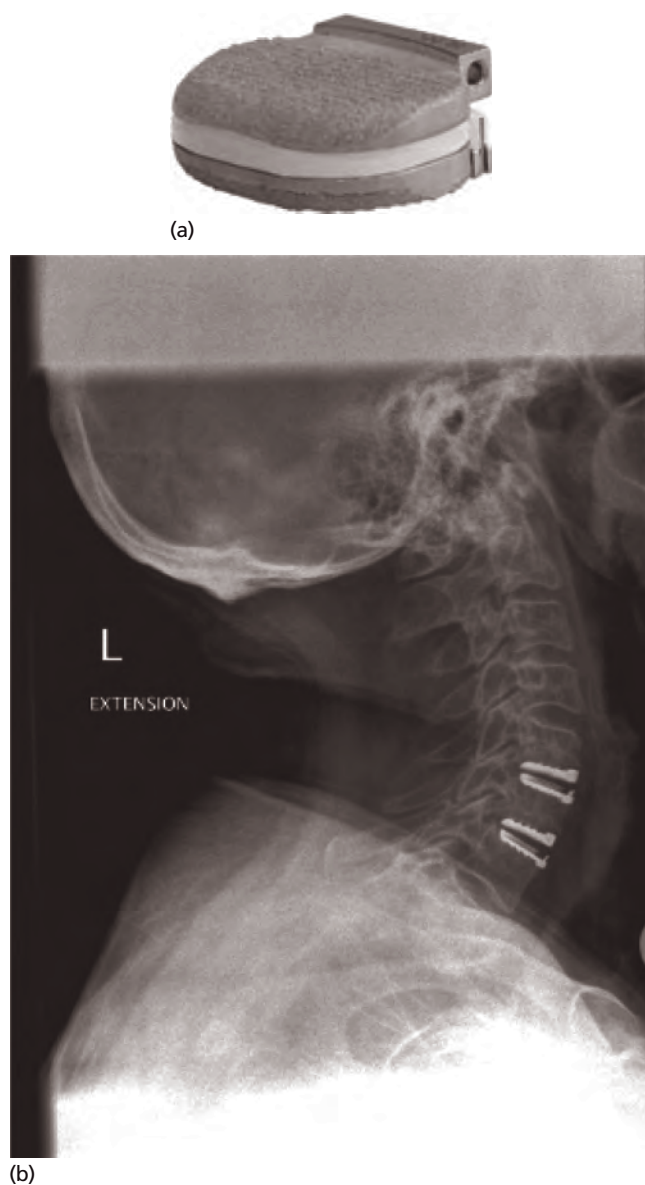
(a) Photograph of artificial cervical disc implant. (b) Lateral cervical spine X-ray showing artificial disc implants at two levels.
